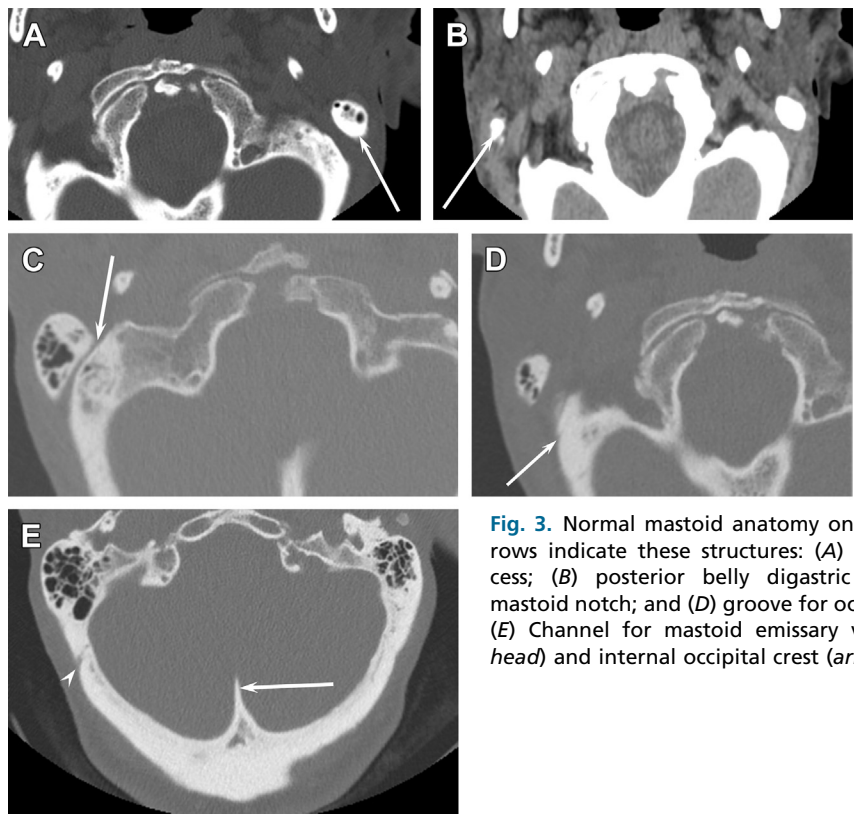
Normal mastoid anatomy on axial CT. Arrows indicate these structures: (A) mastoid process; (B) posterior belly digastric muscle; (C) mastoid notch; and (D) groove for occipital artery. (E) Channel for mastoid emissary veins (*arrow-head*) and internal occipital crest (*arrow*).
